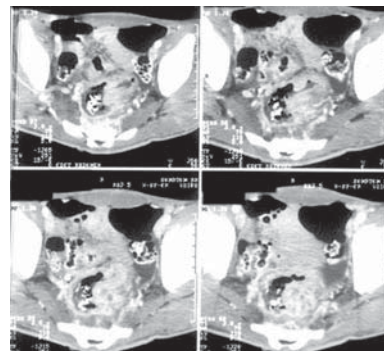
CT scan showing rectosigmoid carcinoma with invasion of pelvic walls posteriorly and posterolaterally with minimal ascites
